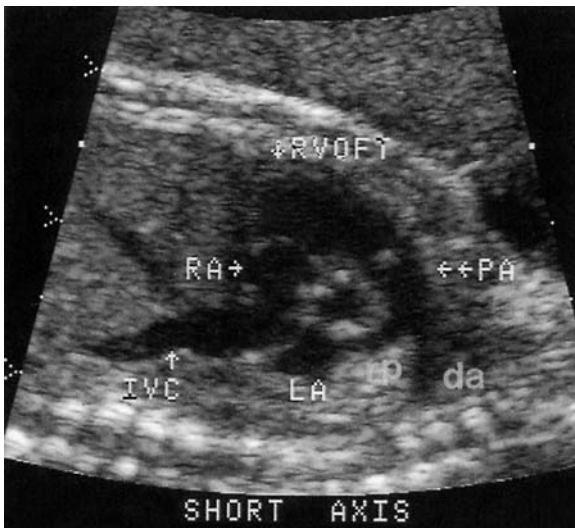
Method for obtaining ventricular short-axis (parasternal) view of the fetal heart at the level of the cardiac base and the origin of the great arteries. *Far left:* Orientation of the transducer plane in relation to the fetal thorax. *Middle:* Echocardiographic plane in relation to the fetal heart. *PA* pulmonary artery, *PV* pulmonary valve, *RV* right ventricle, *TV* tricuspid valve, *IVC* inferior vena cava, *LA* left atrium, *RA* right atrium
